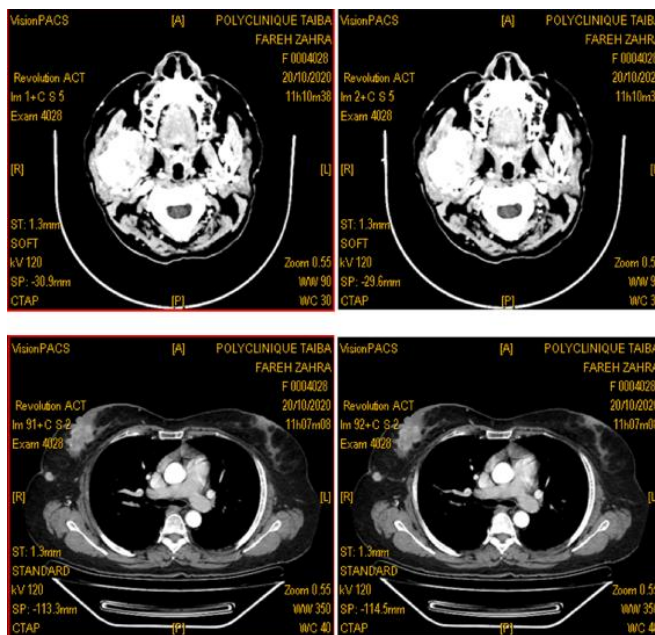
A CT scan objectified the presence of an osteolytic mass of the ascending branch of the right mandible, probably related to a secondary location
